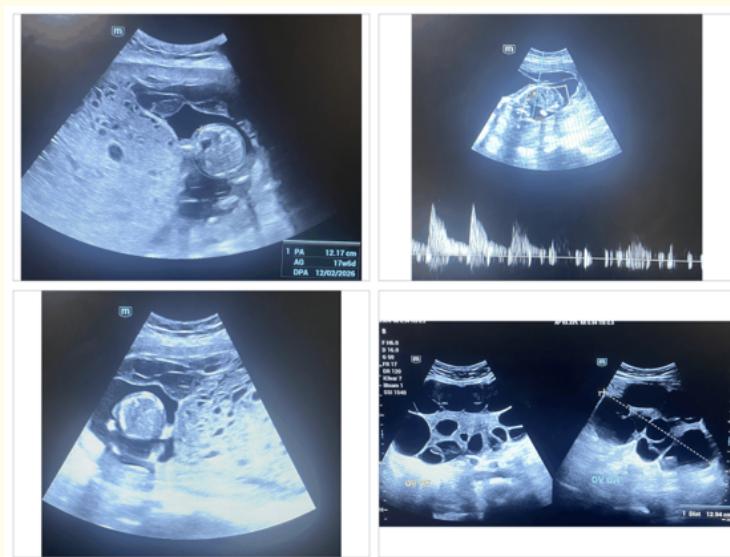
Ultrasound findings in case 1 showing an ongoing singleton pregnancy with biometric measurements below the 3rd percentile, no obvious structural anomaly, a vacuolated honeycomb-like placenta, and bilateral theca-lutein cysts.
